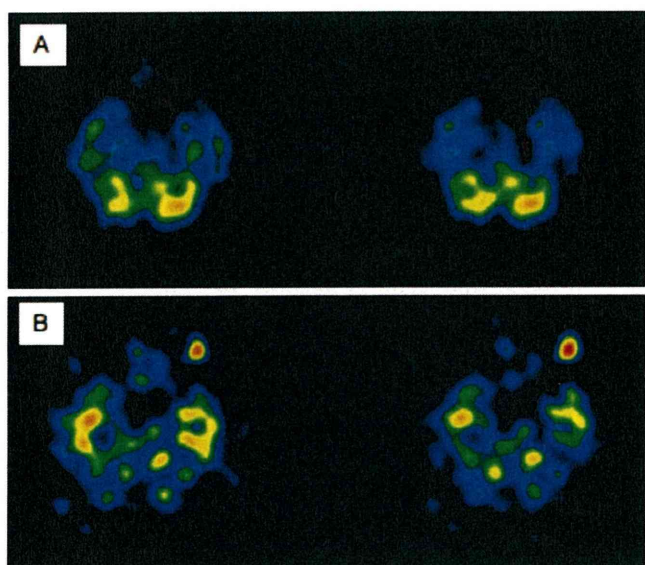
A, B I-123 IMP single photon emission computed tomography (SPECT) early and delayed images of a 69-year-old woman with left uveal malignant melanoma. As the accumulation is obvious, semiquantification can be performed even without a 3D-ROI template.
